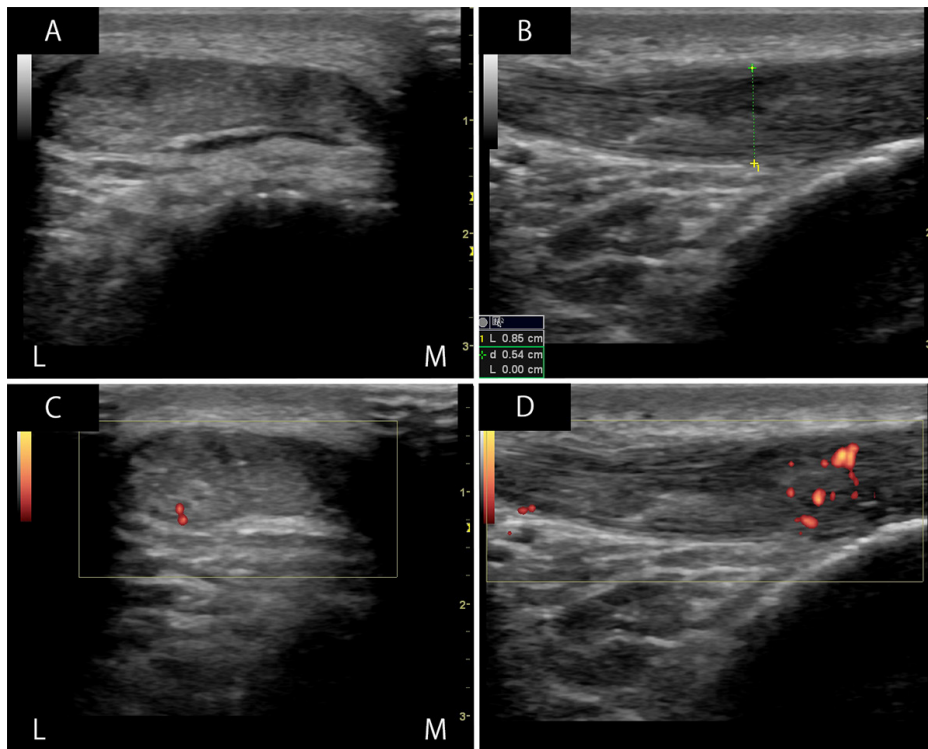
Lateral and short axis ultrasonography of the right patella tendon at 12 weeks. A and B: The injury has healed well and shows similar echotexture as the uninjured portion of the tendon. This is evident on the short and long axes. The distal region remains thickened at 8.4 mm. C and D: Residual vascularity was attributed to ongoing physiotherapy and was not associated with pain symptoms.
